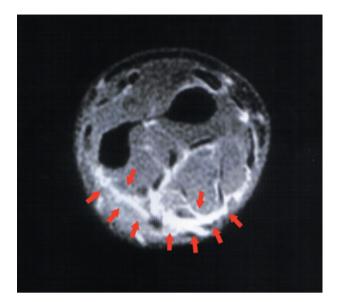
T2 weighted MRI of the forearm in a patient with eosinophilic fasciitis. *Arrows point to inflammatory changes in the fascia
